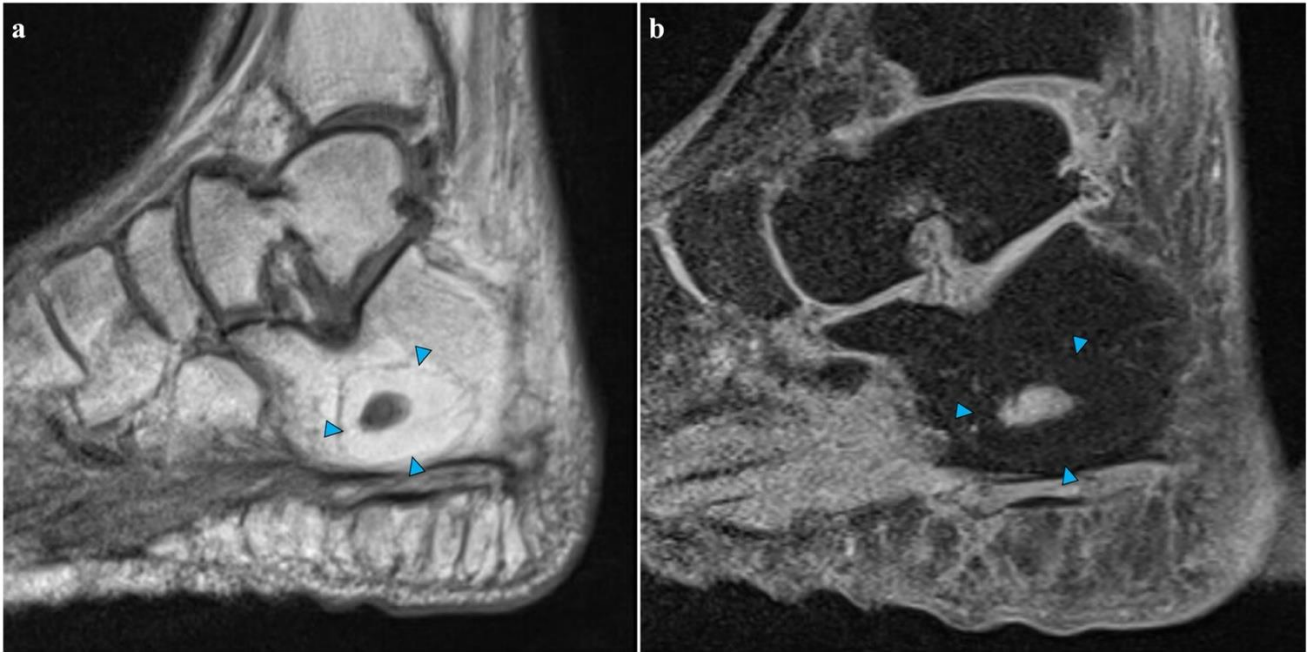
MRI in sagittal T1 (a) and DP fat sat (b) sequences, showing the fatty component of the calcaneal formation in hypersignal T1 and hyposignal on the sequence with fat saturation. The center of the lesion is in hyposignal T1 and hypersignal DP FS, corresponding to an adiponecrotic nidus.
